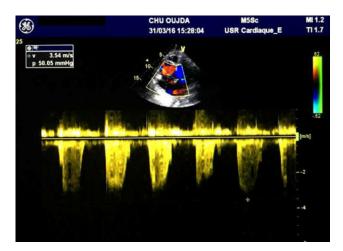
Appearance of the flow of the interventricular communication at the continuous Doppler
